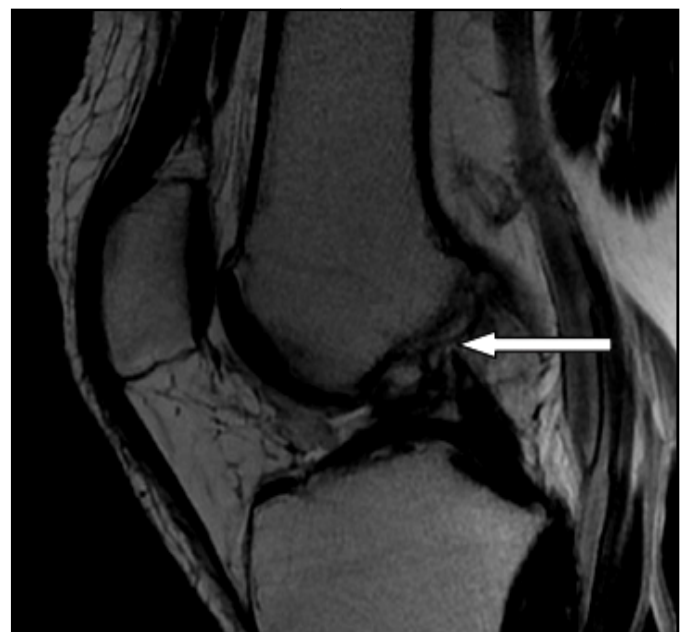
T2 weighted image of knee MRI with T2 Sagittal plane with ACL tear
